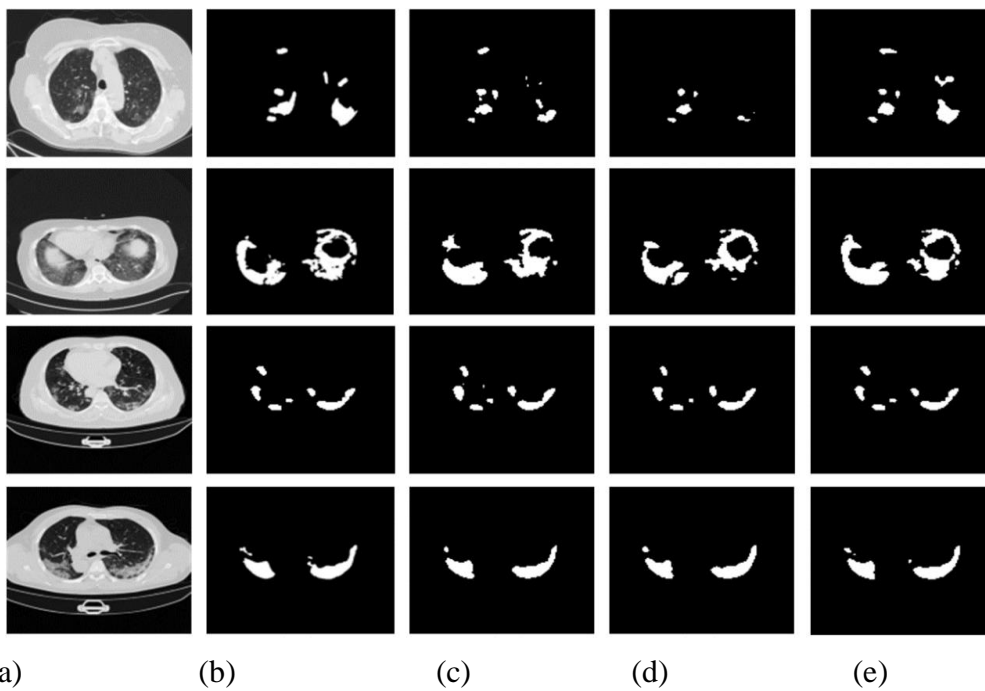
CT image segmented images using various approaches, (a) input, (b) UKMC [26] (c) FCM [23], (d) MOTSU [24], and (e) proposed HMF.
